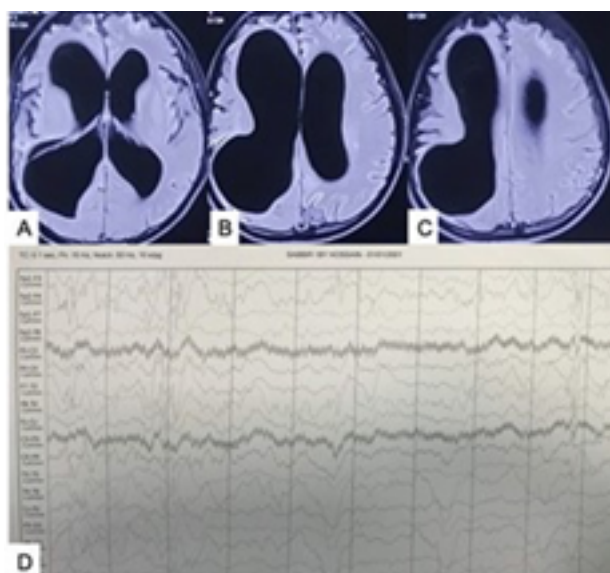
(A–C) MRI of brain axial views showing right hemispheric atrophy (with intractable left-sided focal convulsion to generalization). (D) Scalp EEG tracing showing multifocal electrical discharges mainly from right-sided leads. (But, left-sided lead spikes and sharps are more pronounced due to more parenchymal tissue-paradoxical affects.) Source: Figure by authors.
